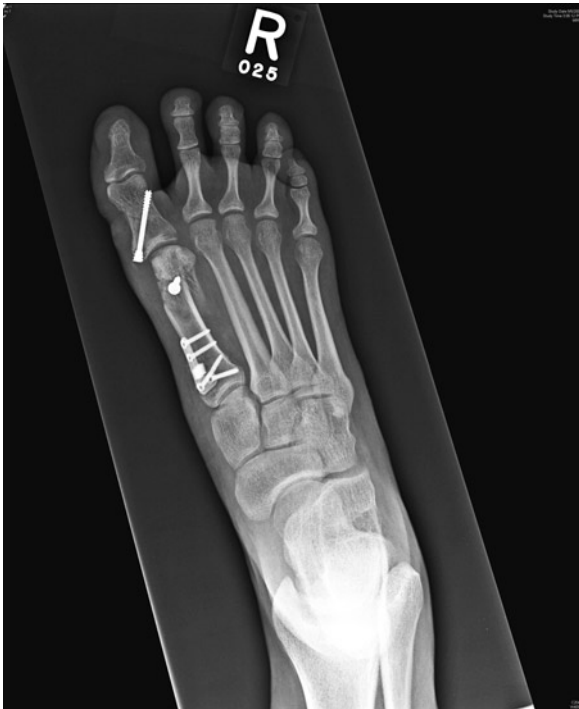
Proximal opening wedge osteotomy. Weight-bearing radiograph of a combination proximal opening wedge osteotomy, biplanar distal chevron osteotomy, and an Akin medial closing wedge proximal phalanx osteotomy at follow-up. The proximal osteotomy tends to increase the DMAA (PASA), thus occasionally necessitating a simultaneous distal correction
